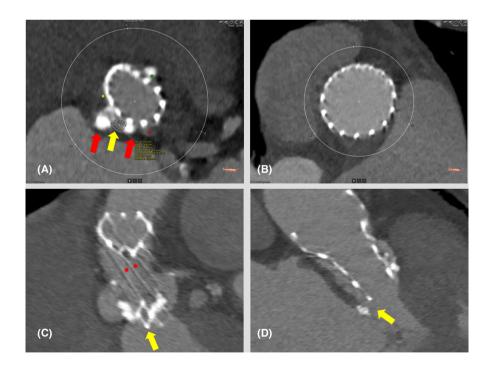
Multi-slice CCT images for PVL closure planification showing (A) short axis of the PVL (yellow arrow), which is located between two calcific nodules (red arrows) at the native-valve annular level; (B) complete apposition of the THV stent frame to the ascending aortic wall, preventing the passage of catheters and guidewires out of the THV stent frame; (C) en-face view of the posterior aspect of the THV, LVOT, native aortic valve and ascending aorta with a centred PVL (yellow arrow) highlighting the 2 spaces aimed for crossing the THV stent frame (red points); (D) fluoroscopic working-view (RAO 30°-CAU 25°) which isolates the PVL (yellow arrow) to the left side. CAU: caudal. CCT: cardiac computed tomography. LVOT: left ventricle outflow tract. PVL: paravalvular leakage. RAO: right anterior oblique. THV: transcatheter heart valve.
